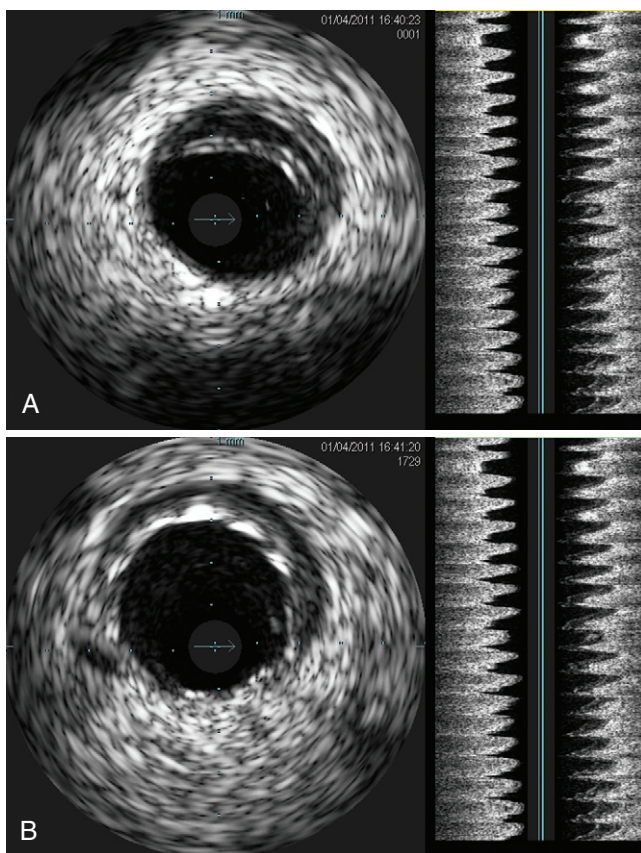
A, Intravascular ultrasound (IVUS) demonstration of intimal flap or dissection. B, IVUS showing stent in place.
